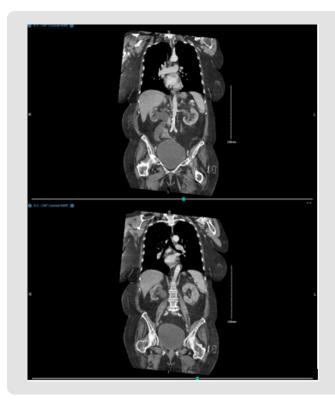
Selected images from the CT Abdomen and Pelvis with Contrast. Impression: Segmental pulmonary emboli most pronounced in the left lower lobe. No right heart strain. Severe right and mild left hydrouteronephrosis with a distended bladder. Punctate calculus in the distal left ureter. Multiple additional bilateral nonobstructing calculi. Right-sided cortical thinning. Dizziness change with bilateral pulmonary nodules. Consider comparison with remote priors versus short interval follow-up at 3 months.
